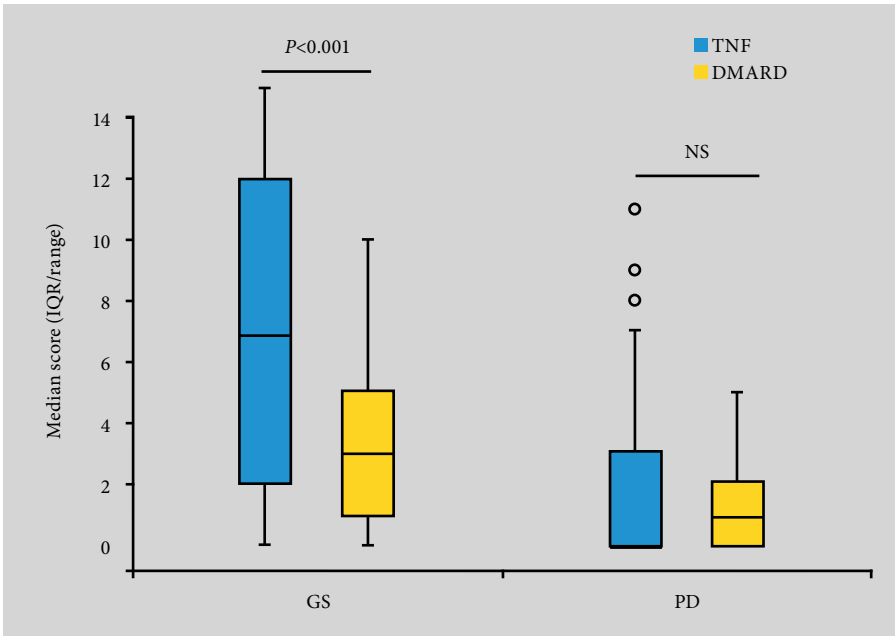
Patients in the combination tumor necrosis factor blocker group had more grayscale synovitis but no differences in power Doppler signal. DMARD, disease-modifying antirheumatic drug; GS, grayscale; IQR, interquartile range; PD, power Doppler; TNF, tumor necrosis factor. Reproduced with permission from Saleem et al [24] ©Wiley.
